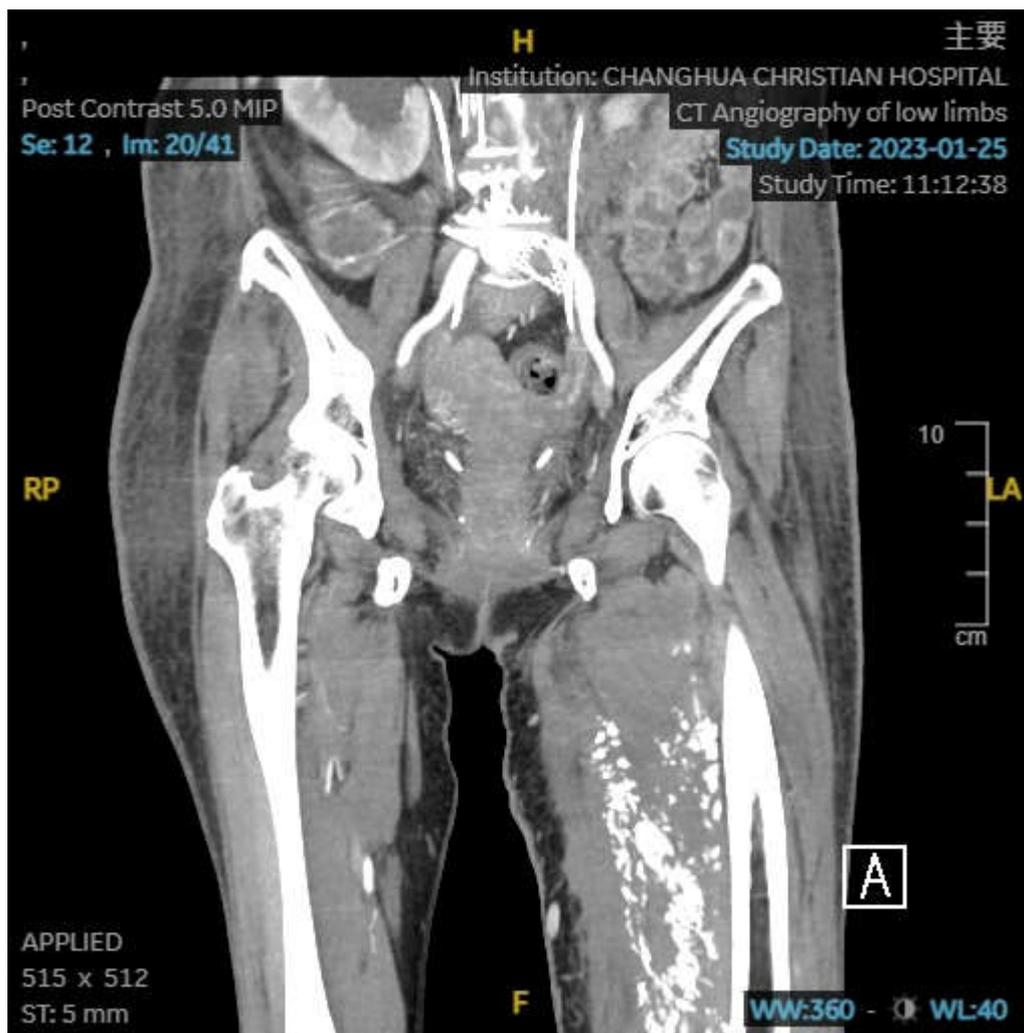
Coronal view of abdominal computed tomography revealed May-Thurner syndrome with left side deep vein thrombosis.
